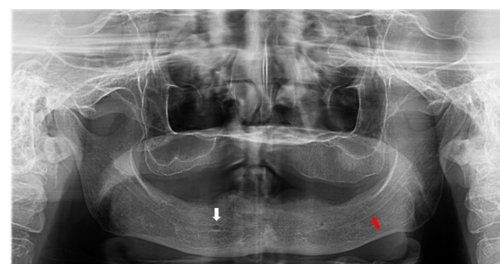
Panoramic radiograph showing mild alveolar ridge resorption where the crest of the alveolar ridge is above the mental foramen (white arrow) and mandibular canal (red arrow) on both side of the mandible.
